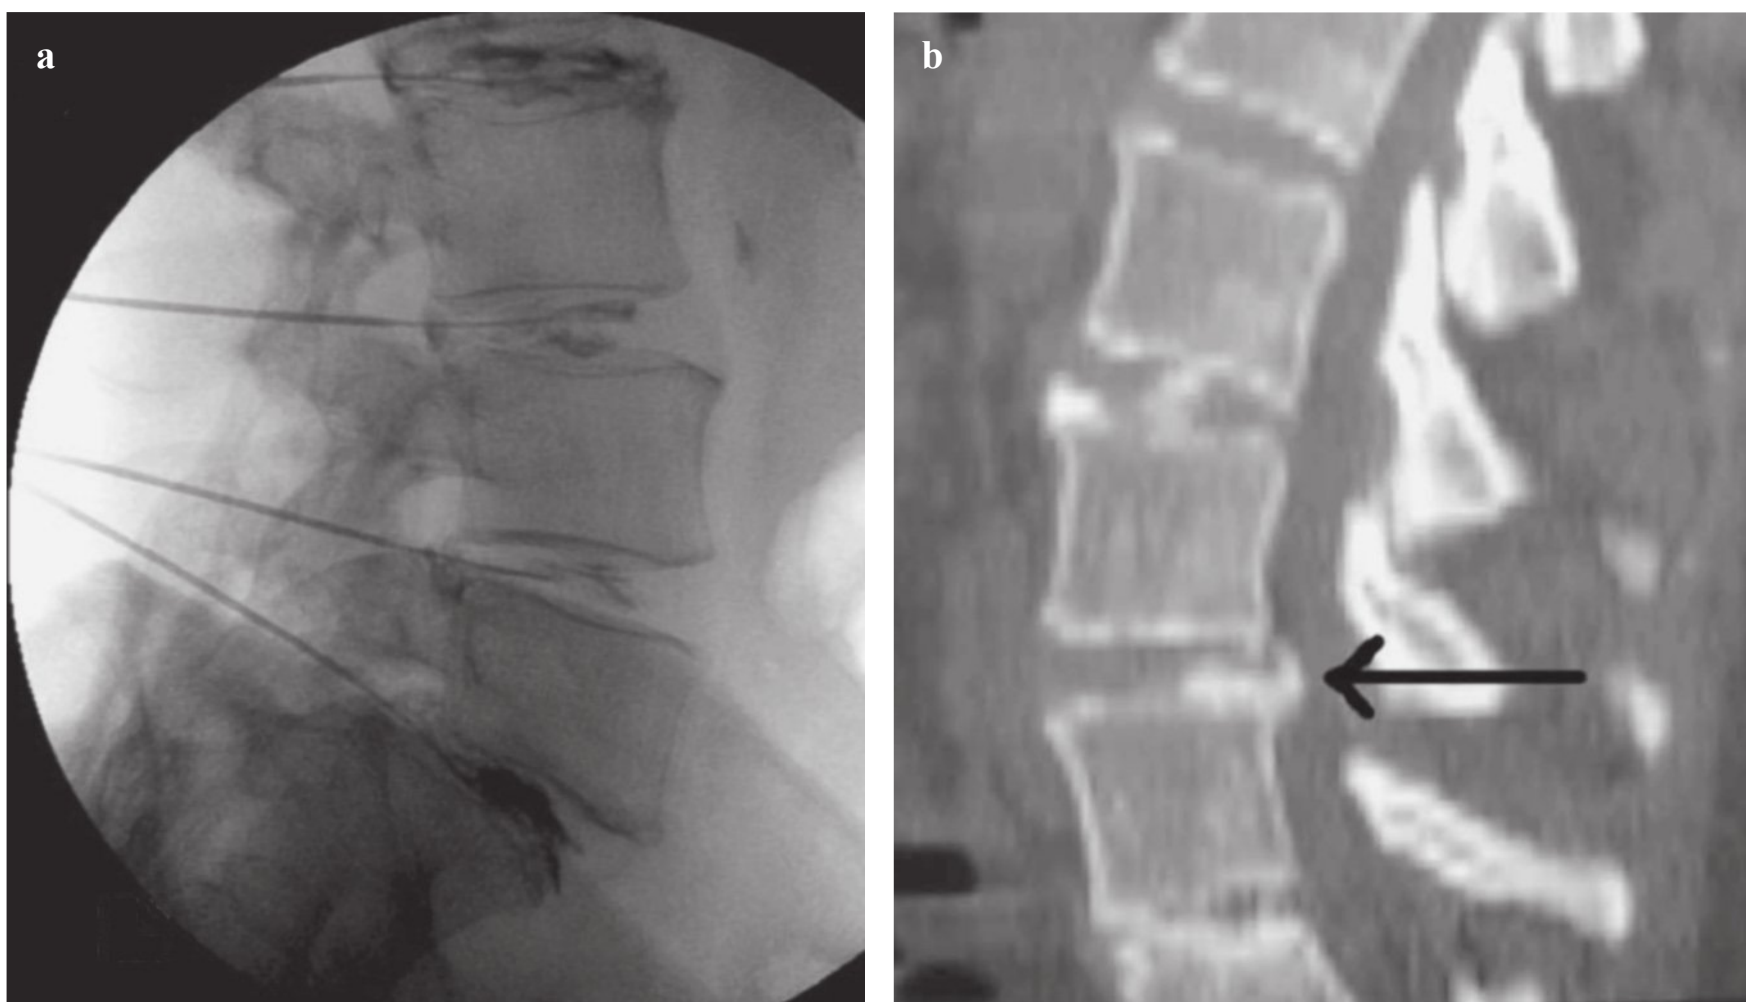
(a) Lateral diskogram demonstrating extravasation of dye at the L5–S1 level suggestive of an annular tear. (b) Computed tomography postdiskography (sagittal) demonstrating extravasation of dye posteriorly at L4–L5.
